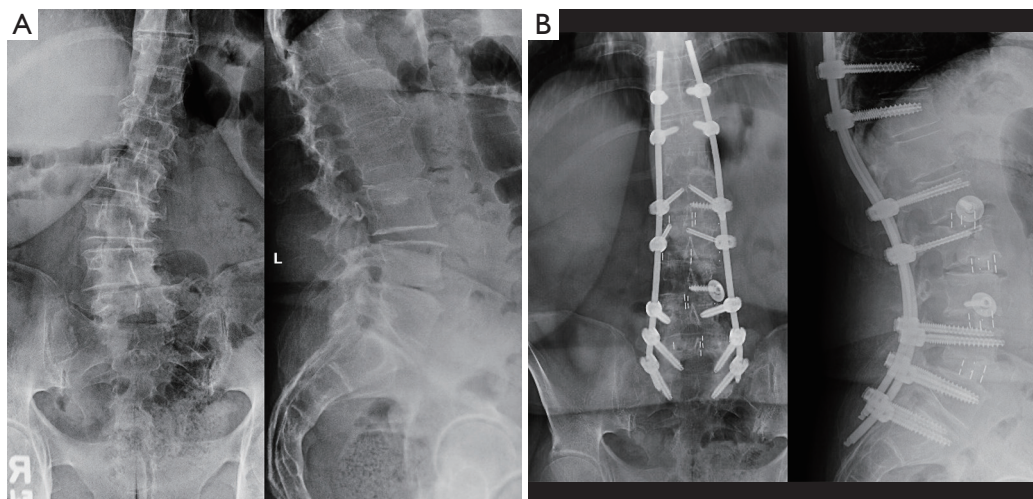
Patient case undergoing MIS-ATP + PPF long fusion with sacropelvic fixation. (A) Preoperative anteroposterior and lateral view X-rays demonstrating adult degenerative scoliosis. (B) Anteroposterior and lateral view X-rays of a MIS-ATP long spinal fusion without pelvic fixation. MIS-ATP, minimally invasive surgery antepsoas; PPF, posterior percutaneous fixation.
